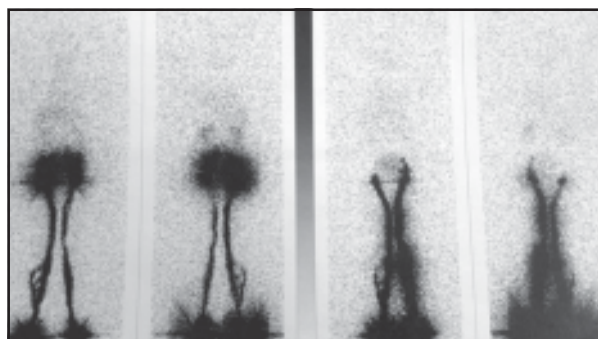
Lymphoscintigram shows normal lymphatics in both lower limbs but complete absence of tracing at abdomen suggesting absence of lymphatic channels.
